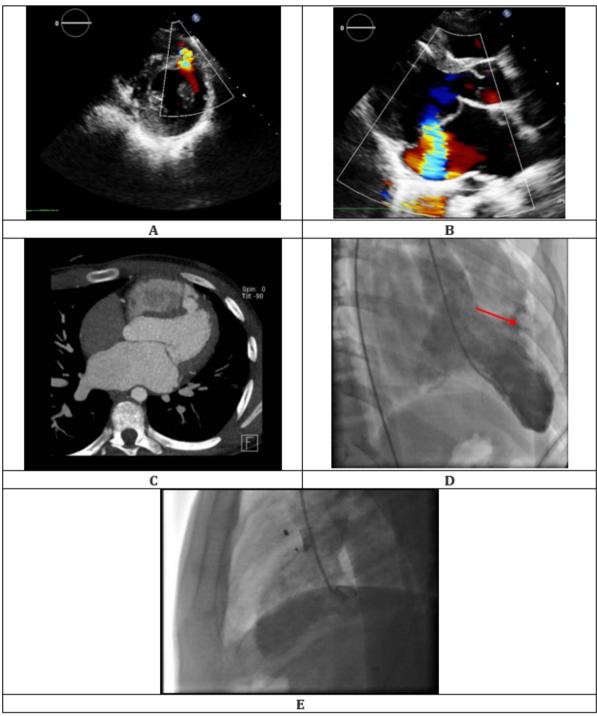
Anterior muscular VSD seen in transthoracic echocardiography (A); Severe MR seen in the echocardiography of the patient (B); Cardiac CT angiography confirmed the presence of a VSD (C); Cardiac Angiography- VSD is shown after dye injection (red arrow) (D); Cardiac Angiography- Occlusion of VSD by an Amplatzer cera liftech muscular occlude (E).
